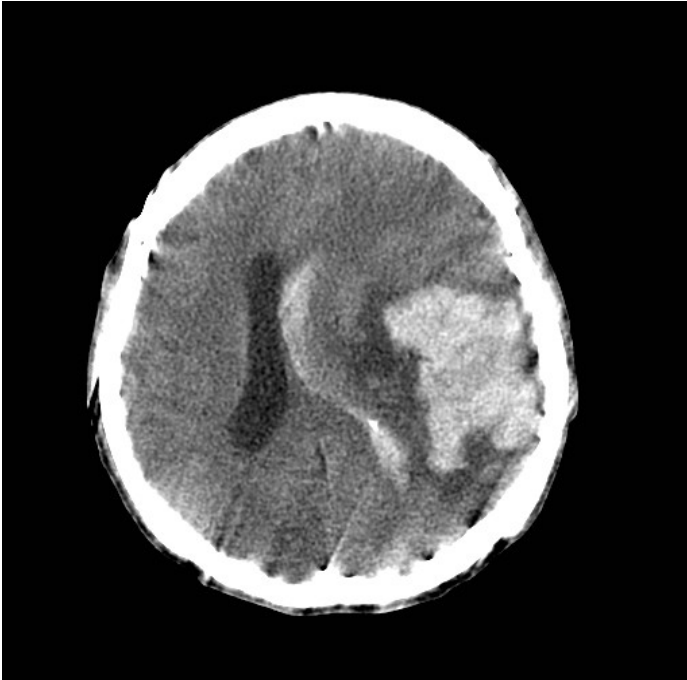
Non-contrast CT scan Brain showing intraparenchymal bleed in the left parieto-occipital region, with perifocal edema, mass effect and midline shift to the right. Extension of the bleed into the ipsilateral ventricle seen.
